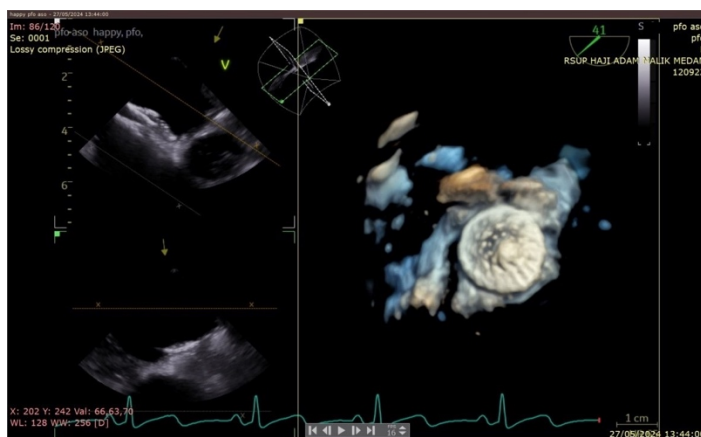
Trans Esophageal Echocardiography findings showed PFO closure using a PFO Occluder size 23/25
